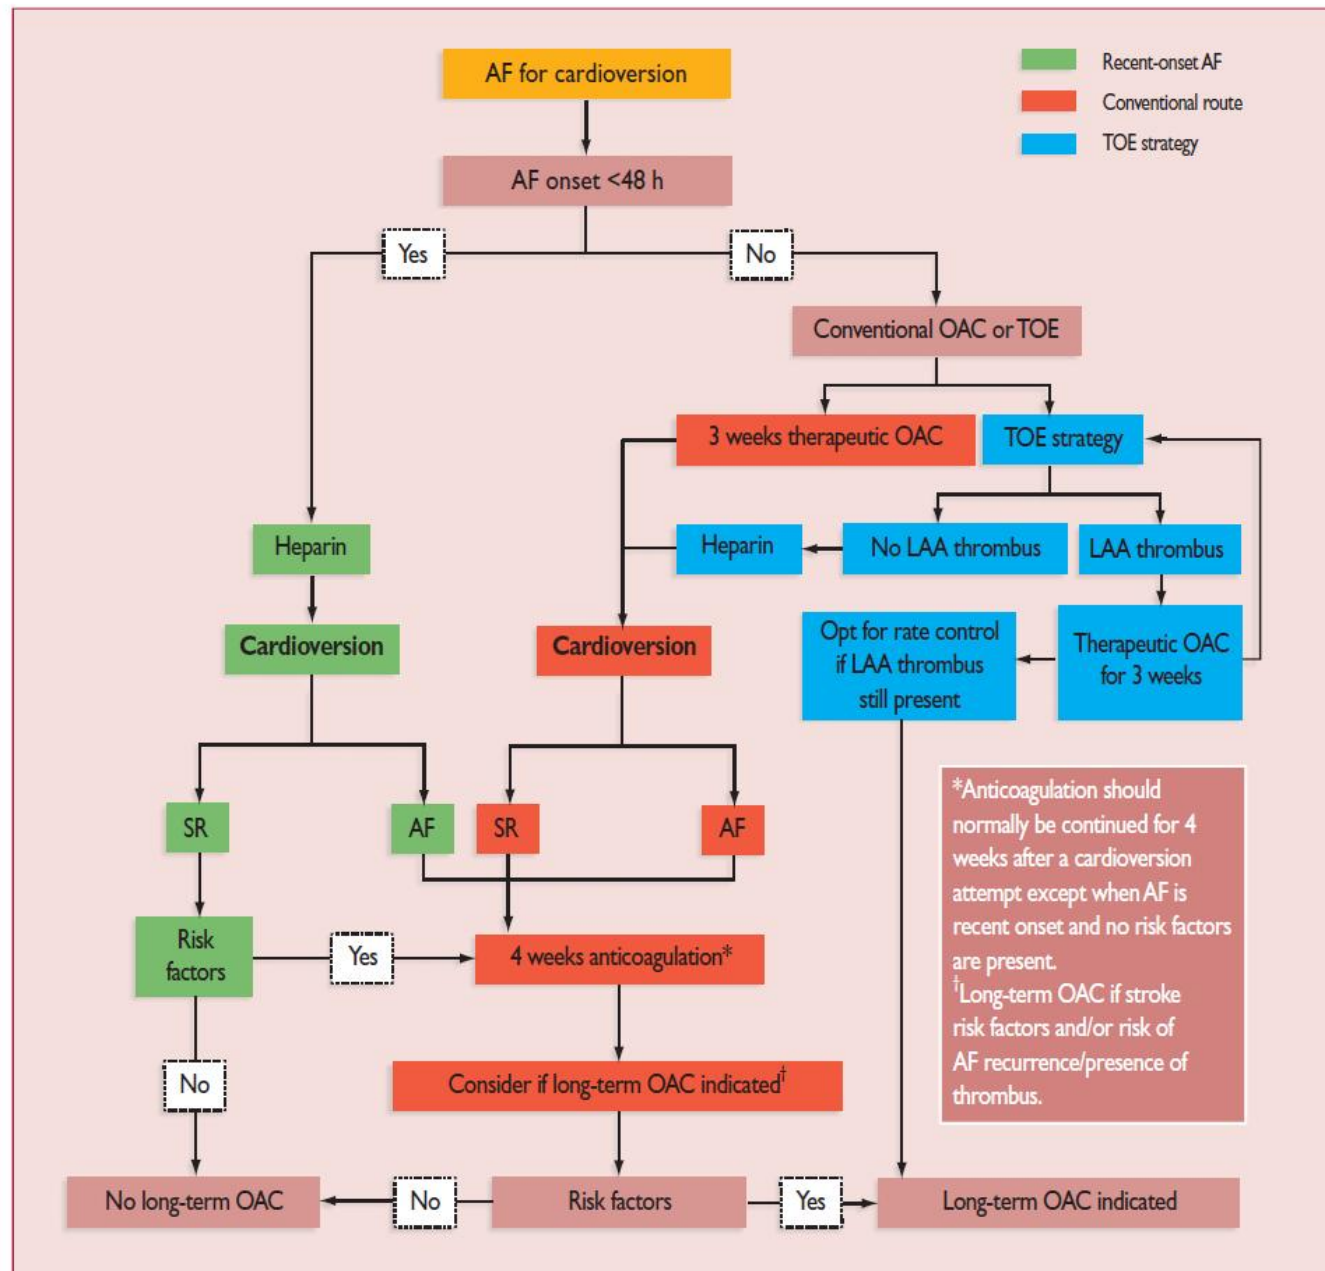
Cardioversion of haemodynamically stable AF, the role of TOE-guided cardioversion, and subsequent anticoagulation strategy. AF = atrial fibrillation; DCC = direct current cardioversion; LA = left atrium; LAA = left atrial appendage; OAC = oral anticoagulant; SR = sinus rhythm; TOE = transoesophageal echocardiography.
